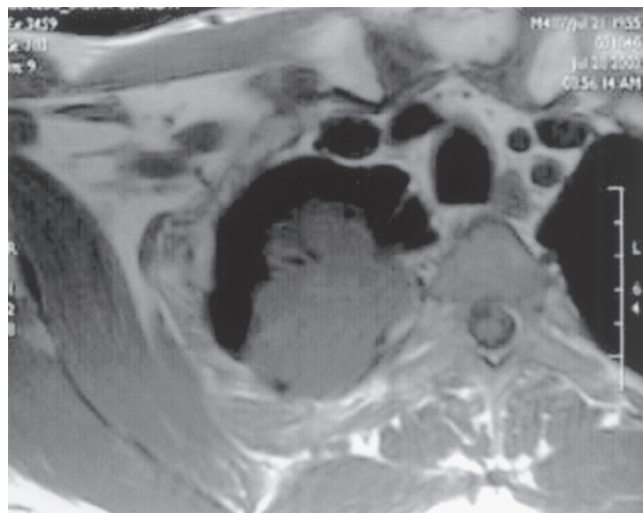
■ Magnetic resonance image that rules out invasion of the intervertebral foramina by the tumor.
